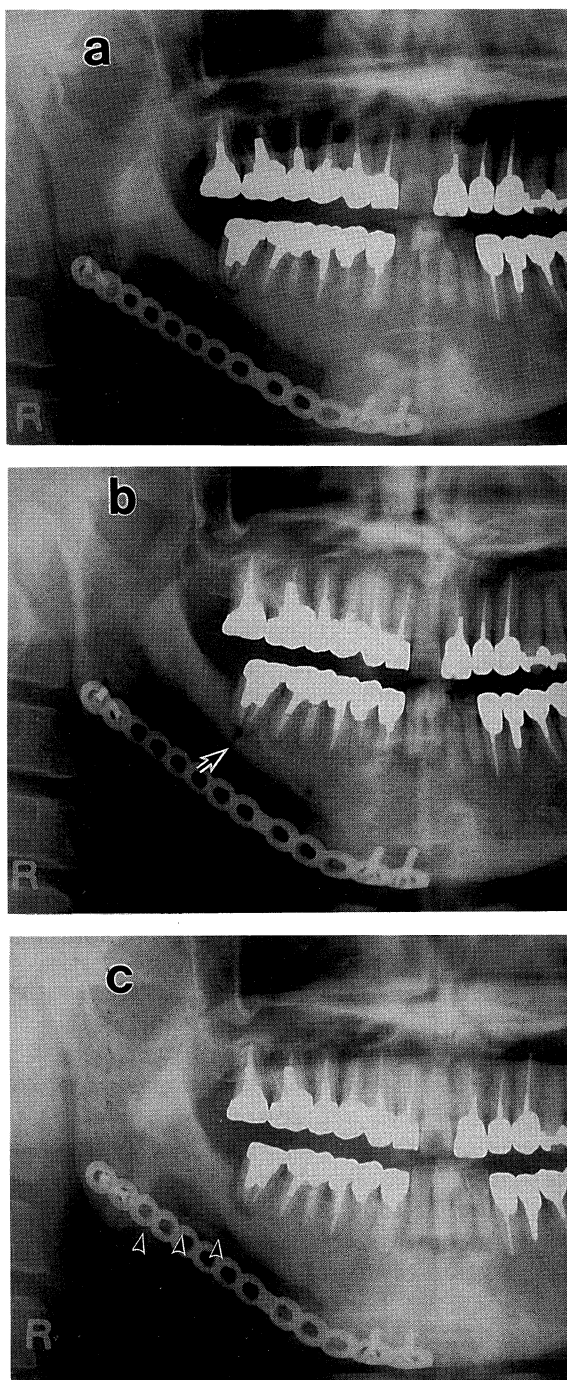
Panoramic radiographs after marginal mandibulectomy
